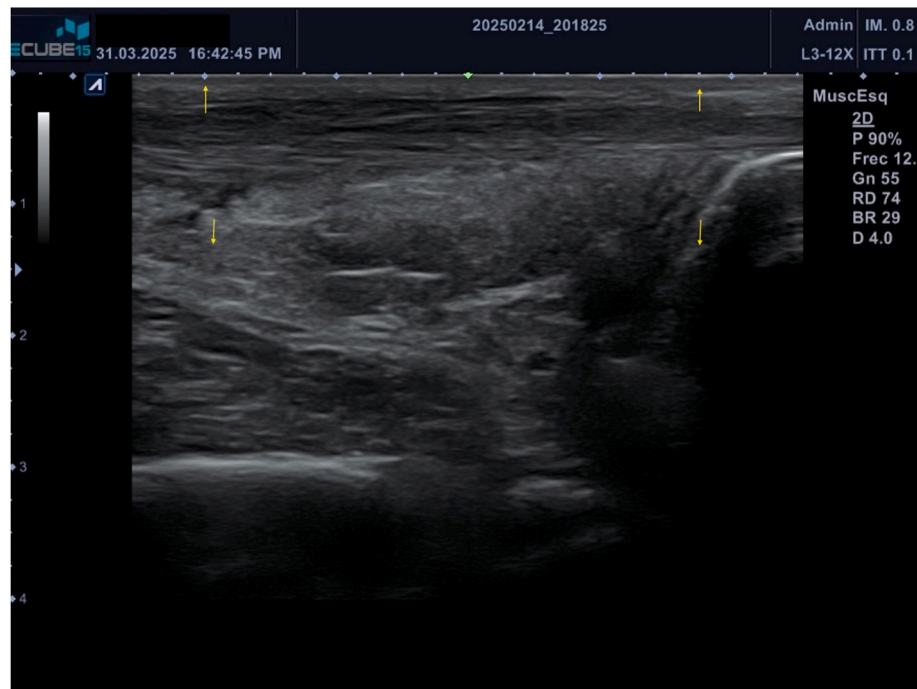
Follow-up visit 5 (6 weeks after injection): Ultrasound image showing significant improvement in fibrosis after 2 electrolysis sessions using a portable multi-option percutaneous electrotherapy equipment. The yellow arrows mark the tendon thickness.
